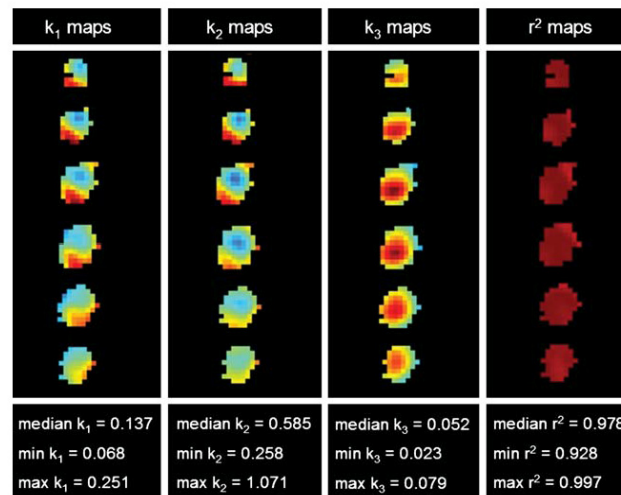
Parametrical maps of k_1 , k_2 , k_3 and r^2 extracted from the kinetic analysis of dynamic ^{18}F -FDG PET. Six slices of an irradiated CWR22 xenograft are shown, together with the tumor's corresponding median and range values for each parameter (in units of min^{-1} for k_1 , k_2 and k_3).
